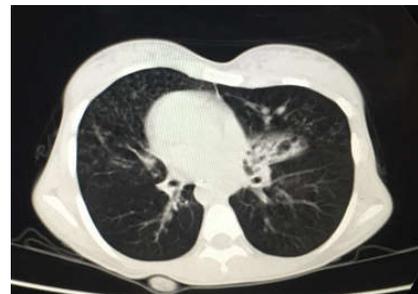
On CT scan thorax, there was dextrocardia, B/L Central bronchiectasis involving left side lingual and right middle lobe. B/L Centrilobular nodular opacity.
